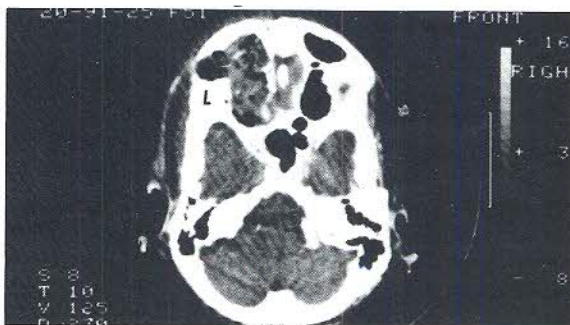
Case 2. CT scan (without contrast) taken 10 days after surgery shows evidence of a postoperative hematoma and air bubbles in the cavity of the mucocele (note that the left/right scanner notation is the reverse of the notation used in Figure 2a).
